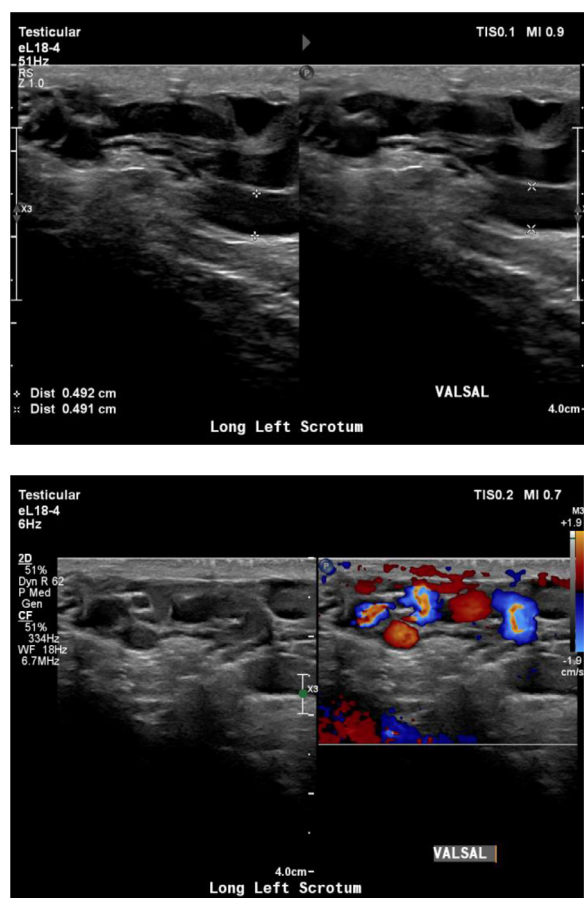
Findings on ultrasound in patient with varicocele. Dilated veins can be seen with retrograde flow during Valsalva.
